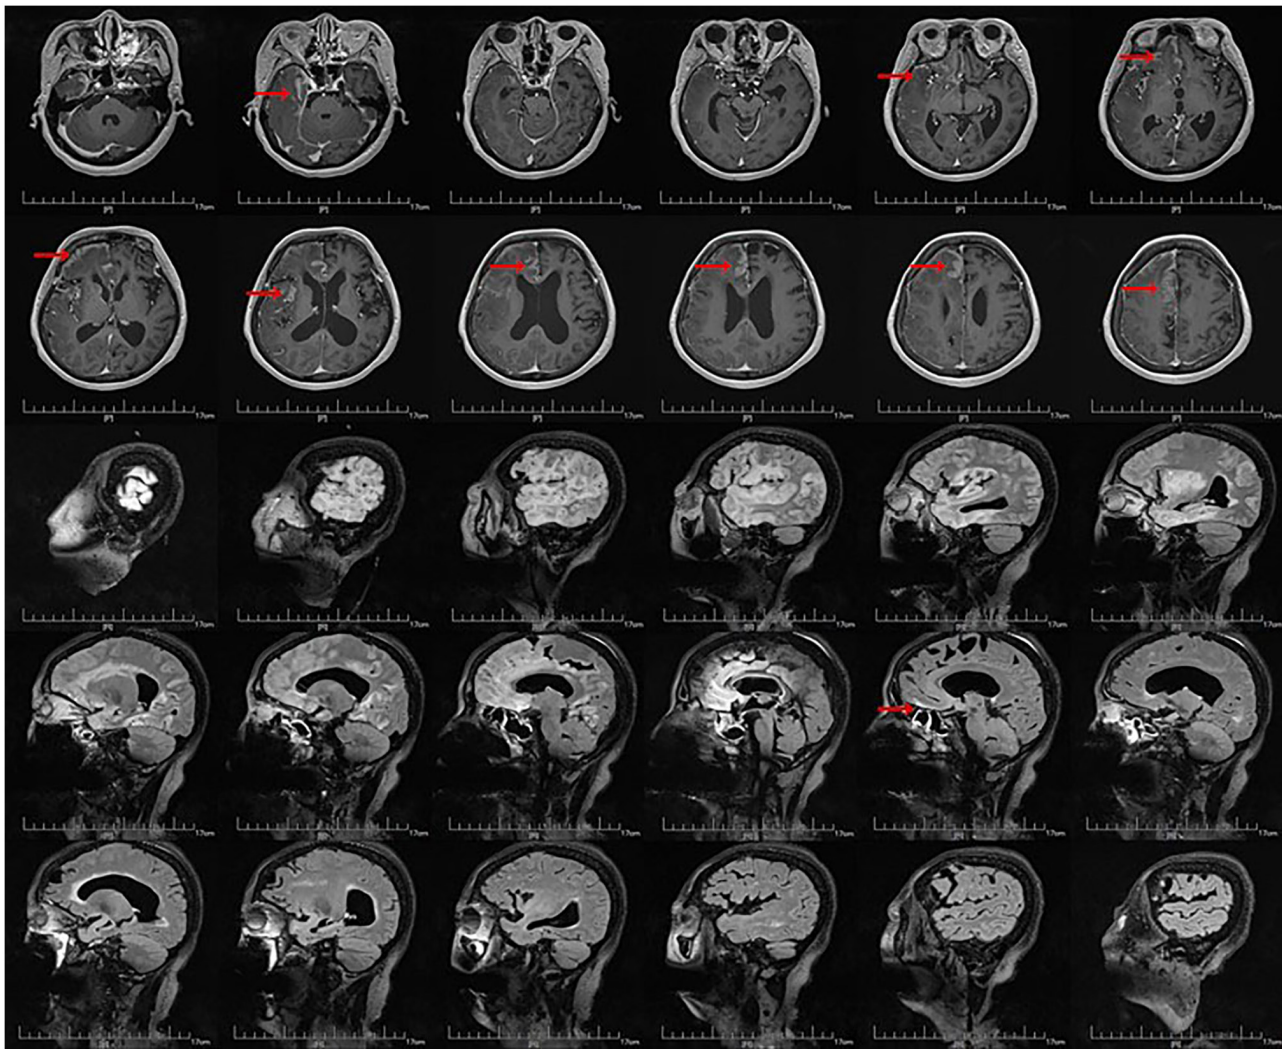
Brain magnetic resonance imaging performed in August 2025, at 5 days post-admission. Contrast-enhanced brain magnetic resonance imaging. Right frontal, temporal and insular lobes showed cortical and leptomeningeal enhancement (red arrow).
